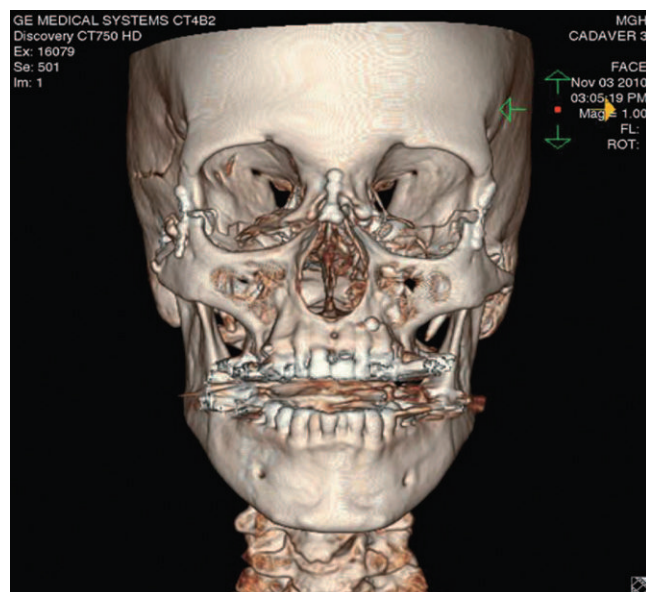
Three-dimensional computed tomographic scans (frontal view) depicting an optimized hybrid skeleton in the recipient.
